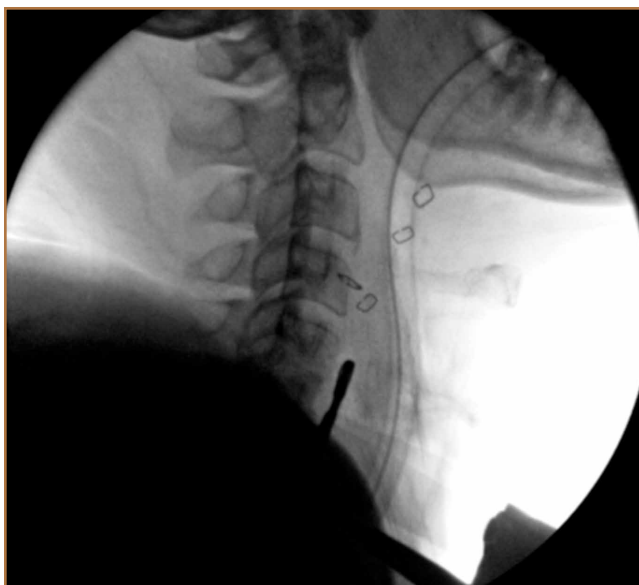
Intraoperative lateral radiograph, showing difficulty in visualizing the inferior cervical spine hardware.
